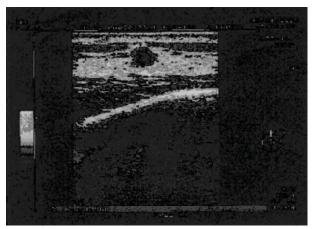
An image of breast cancer in ultrasonography
